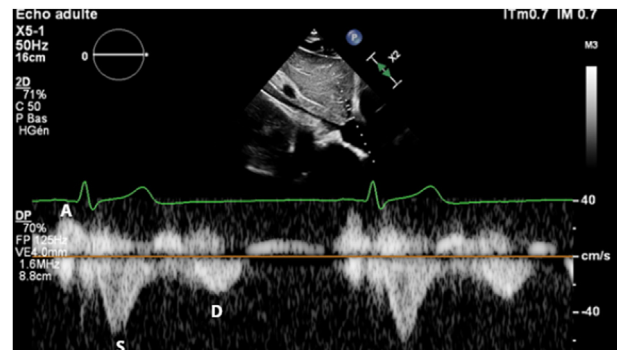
PW doppler of the sus-hepatic vein before it connects with the IVC, showing two negative waves corresponding to the S and D wave with anormal S > D proportion.
